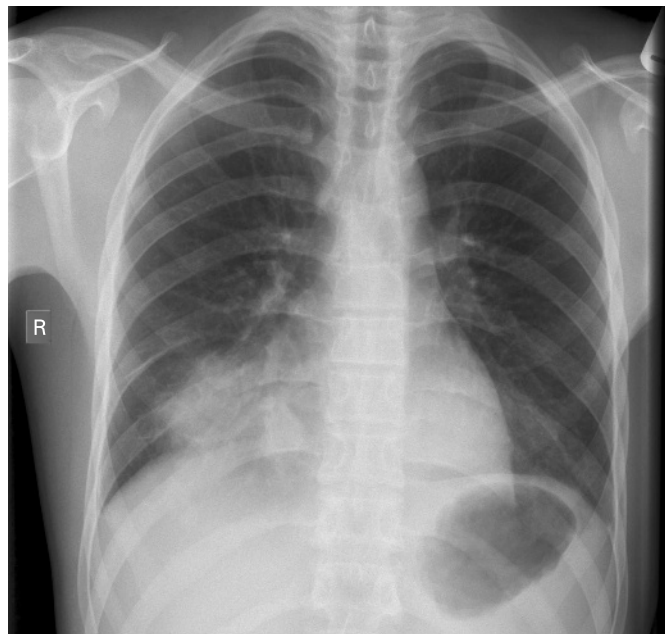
Chest radiograph showing an area of consolidation in the right middle lobe.
